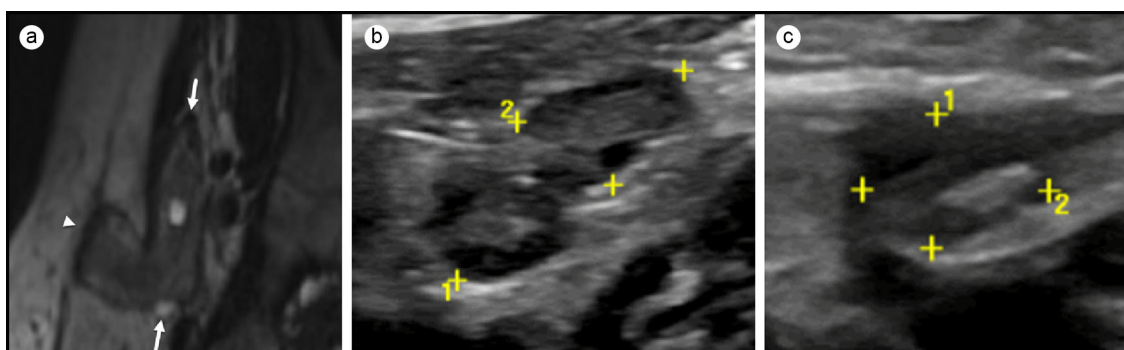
Evaluation of the nonpalpable gonad. (a) Double oblique T2 MRI reformatted image showing the ovarian tissue (long arrows) just within the internal ring of the inguinal canal and the testicular tissue (arrowhead) extending into the canal. (b) Follow-up targeted ultrasound of the inguinal region confirming the typical sonographic pattern of ovarian stroma and peripheral cysts. (c) Follow-up targeted ultrasound of the inguinal region confirming the typical sonographic pattern of hypoechoic testicular parenchyma and hyperechoic mediastinum testis.
